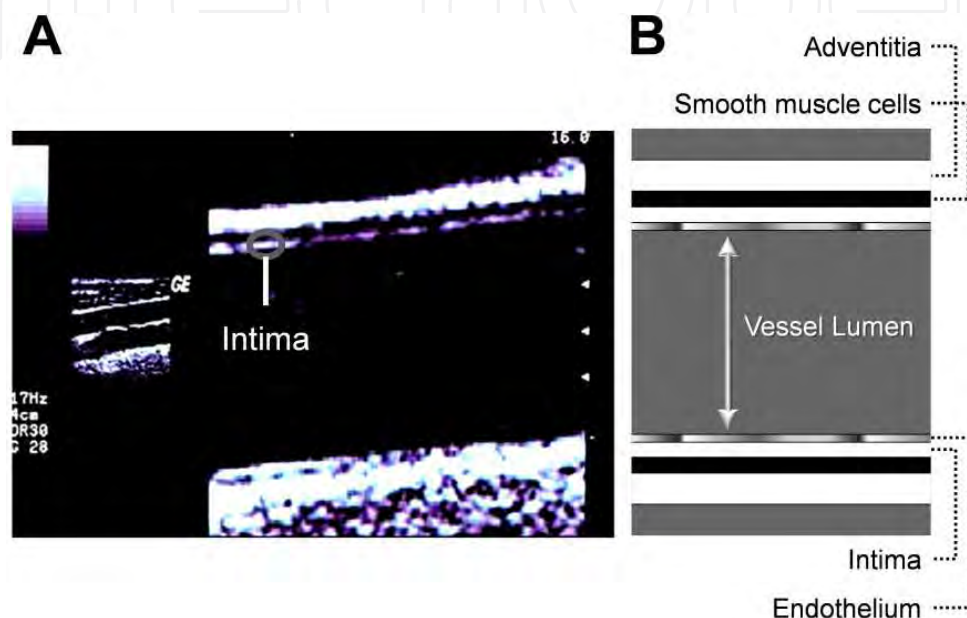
Anatomy of the arterial wall.* (A) A conduit artery imaged in the longitudinal plane using ultrasound. (B) The layers comprising the wall of an artery. Endothelial cells form a continuous layer lining the intima throughout the arterial tree.
